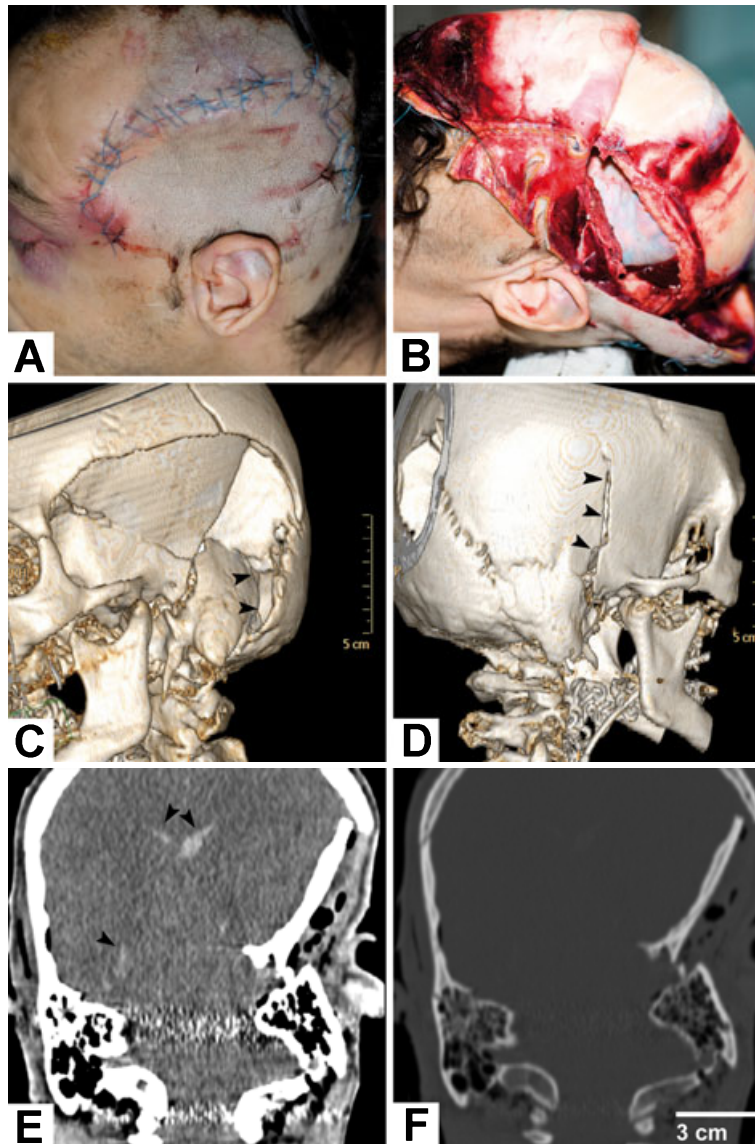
(A) Curved surgical incision at the left side of the head. (B) Lack of portion of the left parietal bone because of the craniectomy. (C–D) 3D volumetric reformations of the skull SSD based on preoperative CT scans. On the left side, the depressed temporo-parietal fracture with a conical shape and an elliptical base. The posterior border of the fracture presents comminuted and diastatic fractures at the lambdoid suture (black arrowheads). On the right side, a temporal bone fracture involving the anterior part of the petrous bone (black arrowheads). (E–F) Coronal multiplanar reconstruction CT images through the petrous bone. Parenchymal window (E): the depressed fracture causes moderate midline shift of brain parenchyma; despite the poor quality of the image because of beam hardening artifacts, diffuse brain edema with loss of subarachnoid spaces and intraventricular hemorrhage (arrowheads) are recognizable; pneumoencephalos and subcutaneous emphysema are also evident. Bone window (F): the left fronto-parieto-temporal fracture presents a larger superior fragment (about 6 cm in diameter) and an inferior fragment involving the mastoid (about 4 cm in diameter); the resultant fracture depression is about 3 cm in depth; other fracture lines are recognizable on the right petrous and parietal bones.
